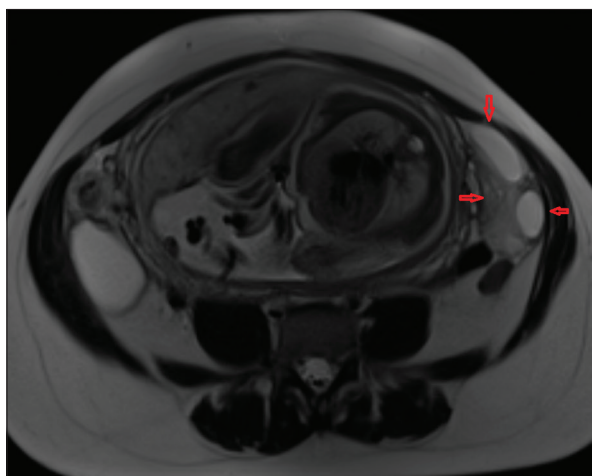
Axial T2-weighted magnetic resonance imaging showing peripherally arranged cysts and findings of stromal edema
